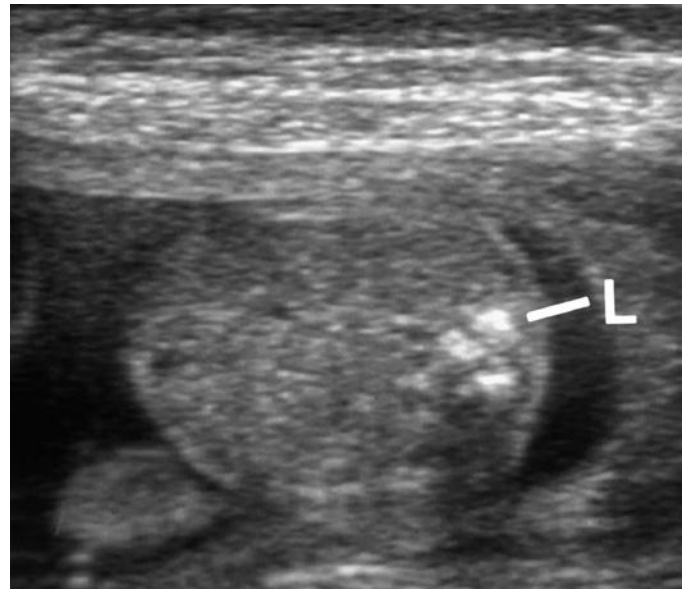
Lumbar vertebra, transverse axial sonogram. The laminae (L) demonstrate early ossification, causing the appearance of "inward angulation" of the posterior arch. (From Filly RA, Simpson GF, Linkowski G: Fetal spine morphology and maturation during the second trimester: sonographic evaluation. *J Ultrasound Med* 6:631, 1987.)
